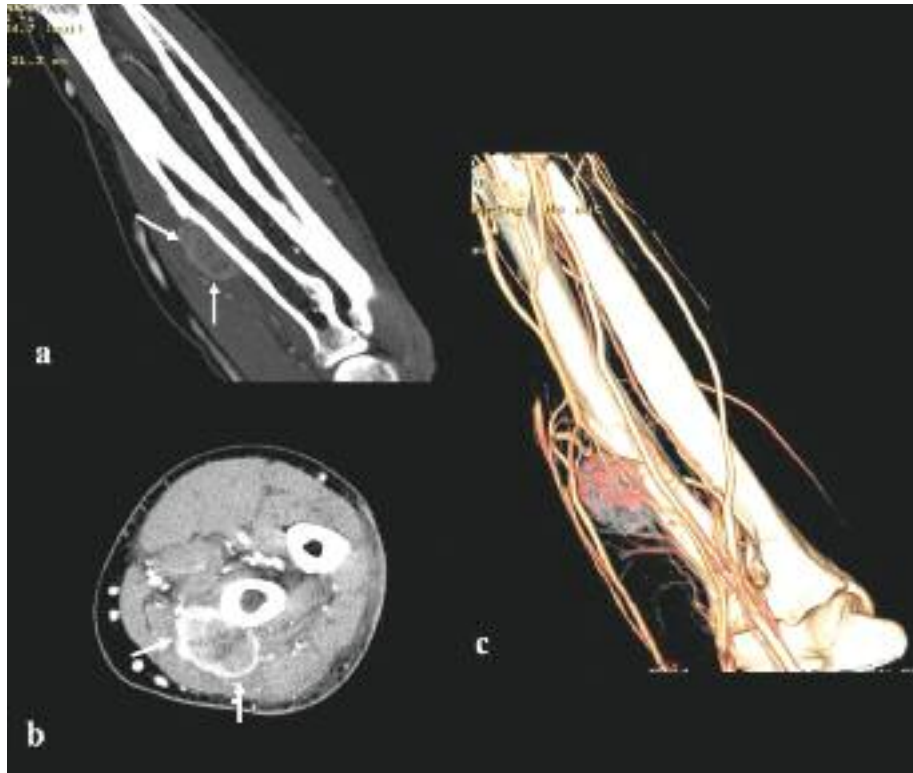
Coronal CT scan showing a well-defined enhanced mass in the antero-lateral compartment of the left forearm muscles (arrows) (a). Axial view after administration of iodine-based contrast material (arrows) ; (b). Three-dimensional CT reconstruction showing the same mass (c).
